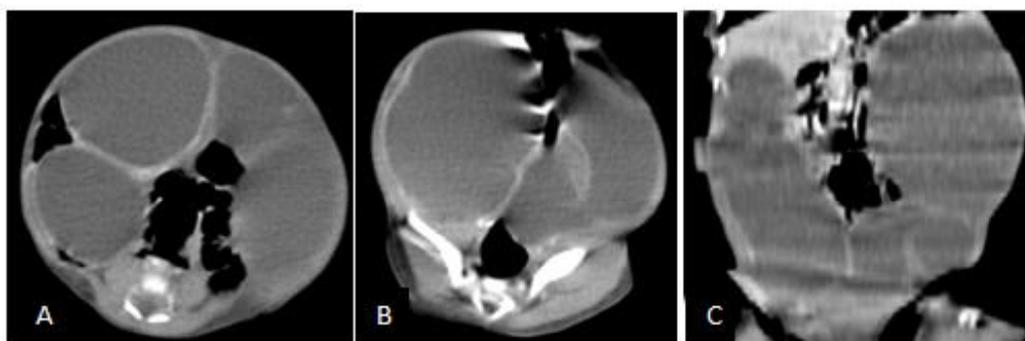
Abdominal-pelvic CT in axial (A and B) and coronal (C) sections with PDC injection
